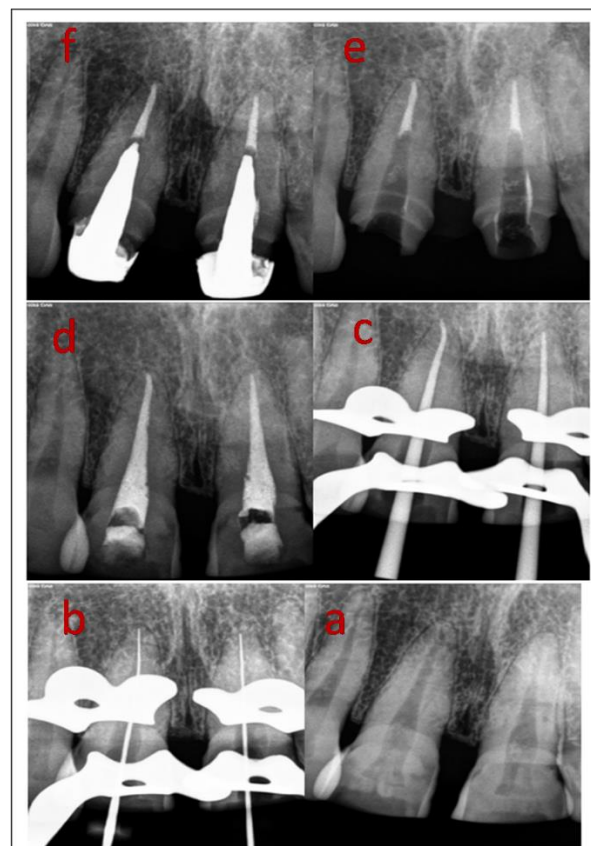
(a) Preoperative radiograph, (b) Working length, (c) Master Cone, (d) Obturation, (e) Post Space Preparation, (f) Post cementation
